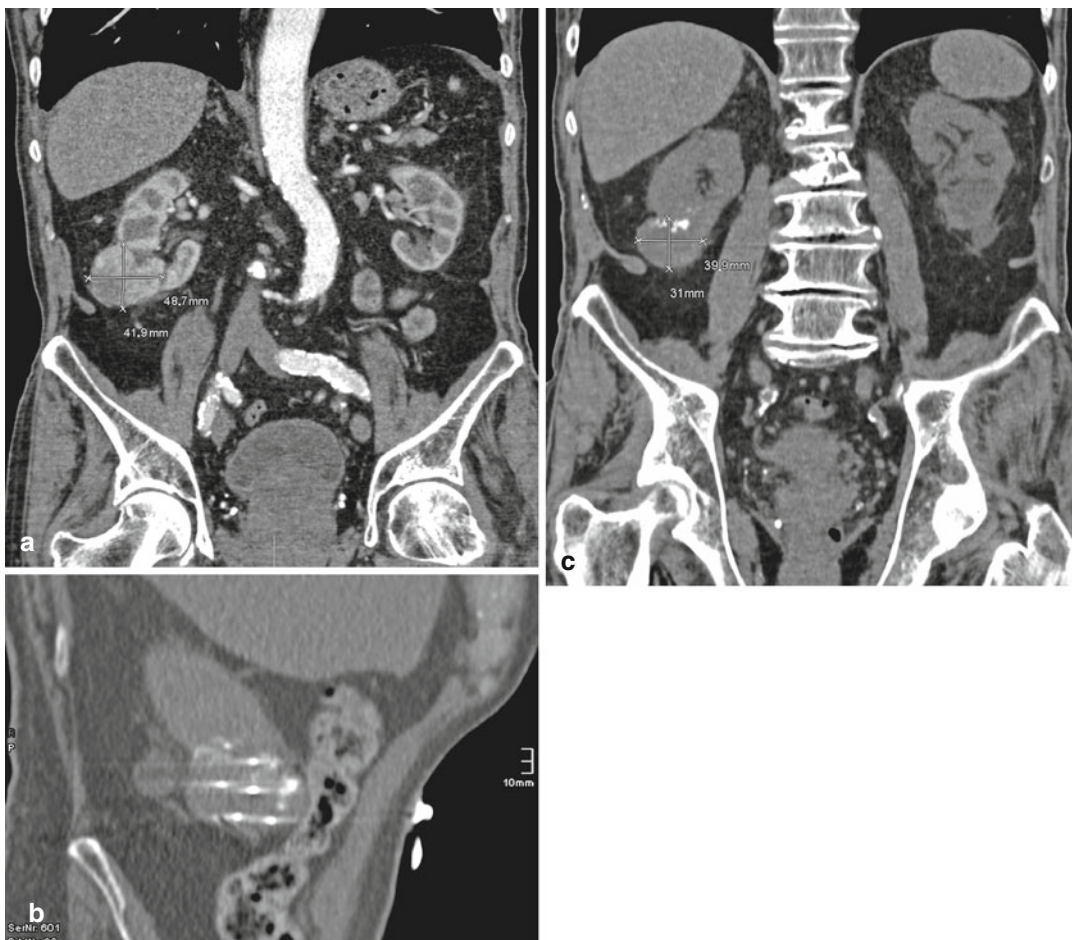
IRE in a patient with right-sided renal cell carcinoma: the initial CT scan shows the almost 5-cm-measuring renal cell carcinoma in the lower third of the right kidney (a). An oblique reconstruction from a CT
